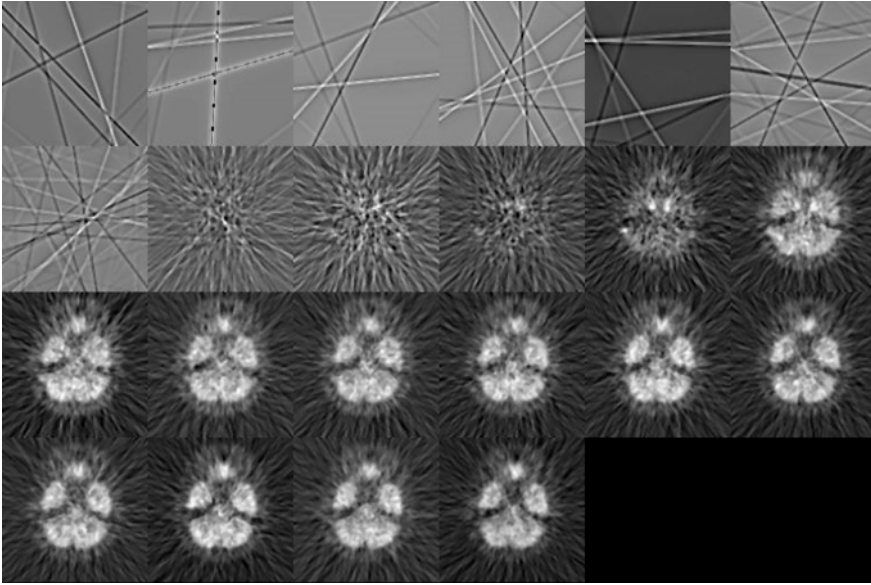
A sequence of dynamic neurologic FDG-PET images sampled at the level where the internal carotid arteries are covered. Individual images are scaled to their own maximum.
